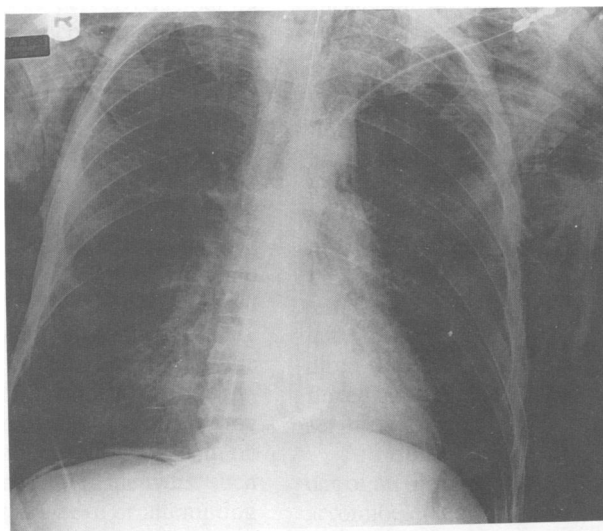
An anteroposterior x-ray film of the chest was taken 2 days after the patient had a normal roentgenogram.
